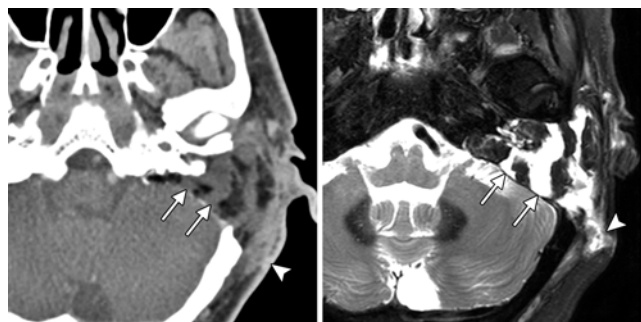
Fat graft necrosis with CSF fistula. This patient presented with drainage of CSF from the wound after schwannoma resection. Axial CT image (left) and axial T2-weighted MRI study (right) showing striated bands of fluid (arrows) traversing the fat graft, extending to the incision site (arrowheads).
